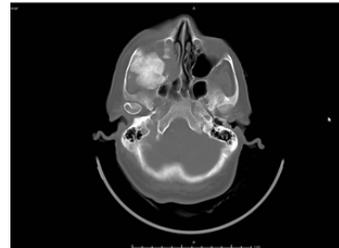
Computed tomography shows a radiolucent, expansile, lytic lesion with central radio-opacity involving maxillary sinus.
